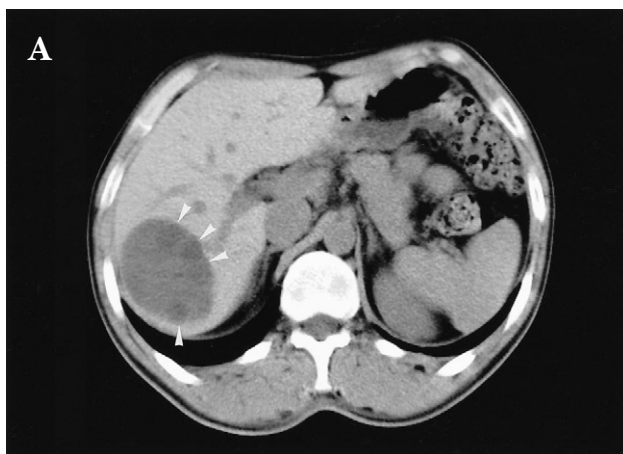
(A) Unenhanced computed tomography (CT) scan shows an ovoid low-density mass in the right lobe of the liver. The mass has the typical peripheral location of daughter cysts (arrowheads) within the mother cyst. There is no definite calcification of the pericyst. (B) Contrast CT scan reveals no obvious enhancement in the mass.
